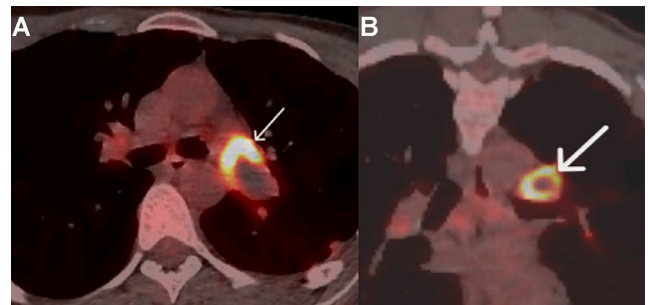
(A) Axial ^{18}F -FDG PET/CT fused. Thrombus in the left main pulmonary artery which is intensely FDG-avid at its proximal aspect concerning for tumor thrombus. (B) Coronal ^{18}F -FDG PET/CT fused at the same level demonstrating intensely FDG-avid thrombus.
